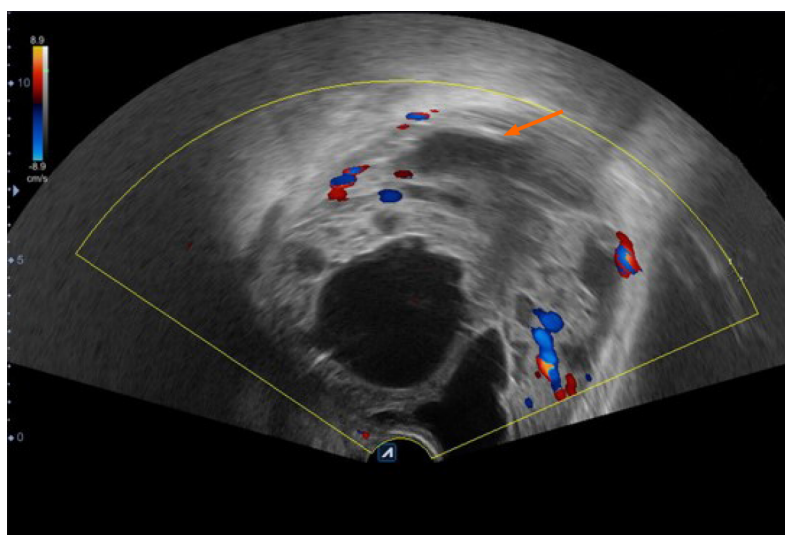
Color-ultrasound of the urinary bladder area suggested an enlarged prostate of approximately 9.29 cm × 10.98 cm × 9.62 cm in size protruding into the urinary bladder. Multiple cystic, hypoechoic lesions were detected in the prostate gland, and no evident signs of blood flow were seen in the hypoechoic lesions (arrowheads). Prostate hyperplasia with cystic degeneration was considered.
